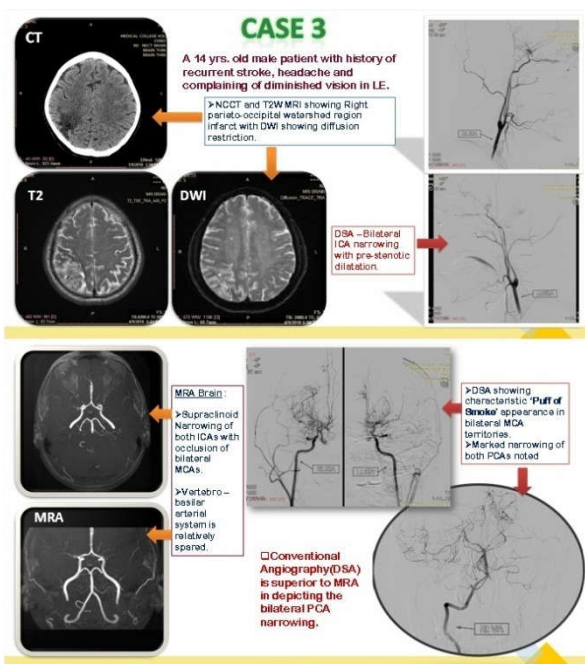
Case study showing NCCT, MRI, MRA and DSA findings in a 14 years old male diagnosed with Moyamoya disease.
